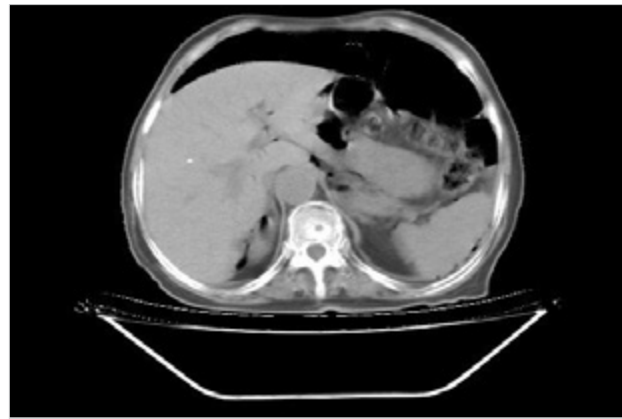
Free intra-abdominal air on upper sections of abdominal computed tomography
